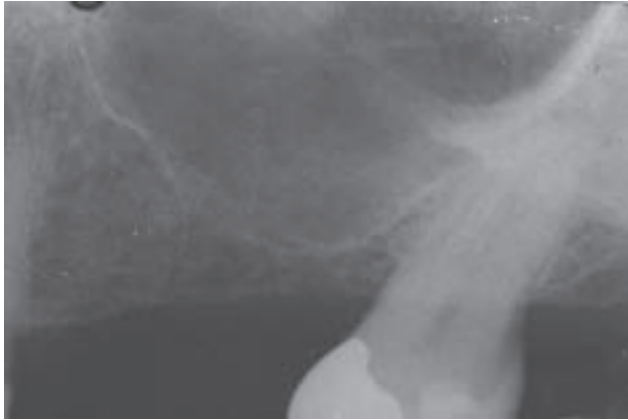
Periapical radiograph suggesting that there is a slope to the sinus wall at the maxillary left second premolar site which could complicate the use of osteotomes to create the infracture of the wall.
